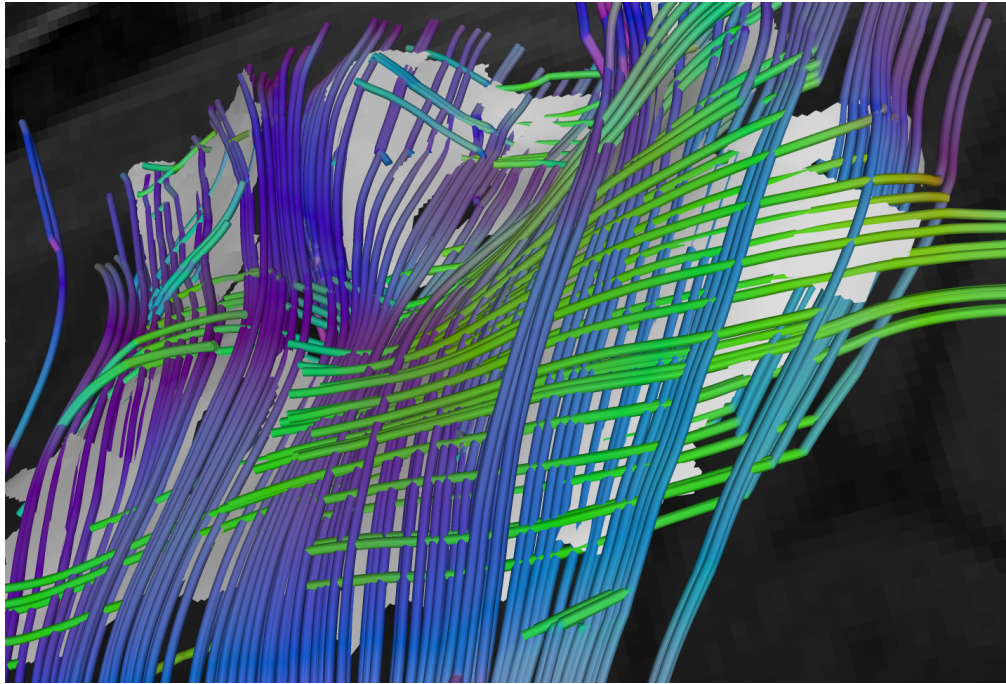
We observed that seeding crossing fiber tractography on DT-MRI streamsurfaces often results in streamlines that remain close to the surface, which is shown here in gray. This specific example shows part of the corona radiata.
